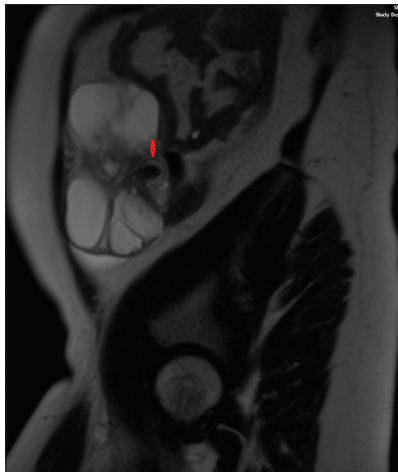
Sagittal T2-weighted magnetic resonance imaging showing suspected whirlpool sign in the vascular pedicle
